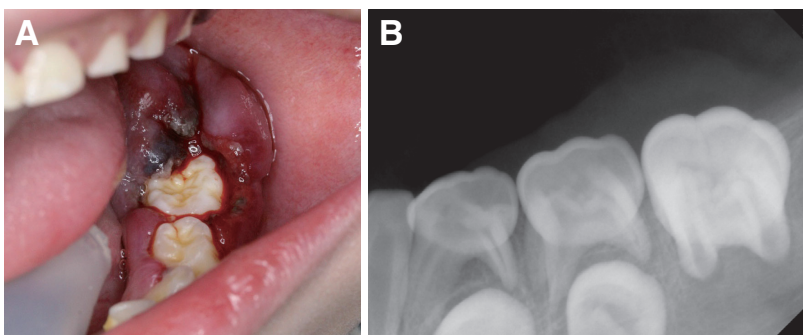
(A) Intraoral photograph and (B) Periapical radiograph taken on the patient's first visit to the clinic. Gingival overgrowth is observed on mandibular left molar area.
